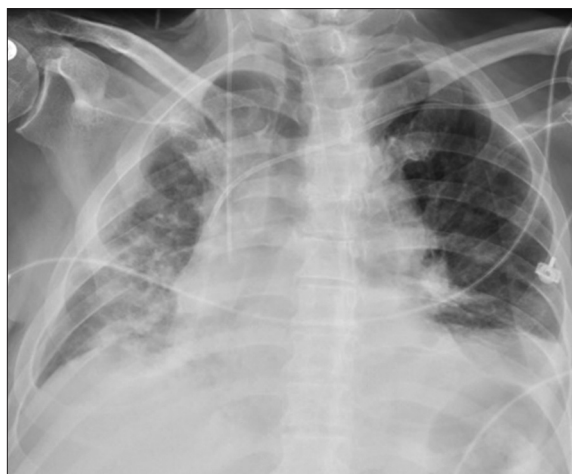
Chest X-ray on day 42 after first nivolumab or 7 days after infliximab showed resolved immune-related pneumonitis. The patient had also been successfully weaned from invasive ventilation
